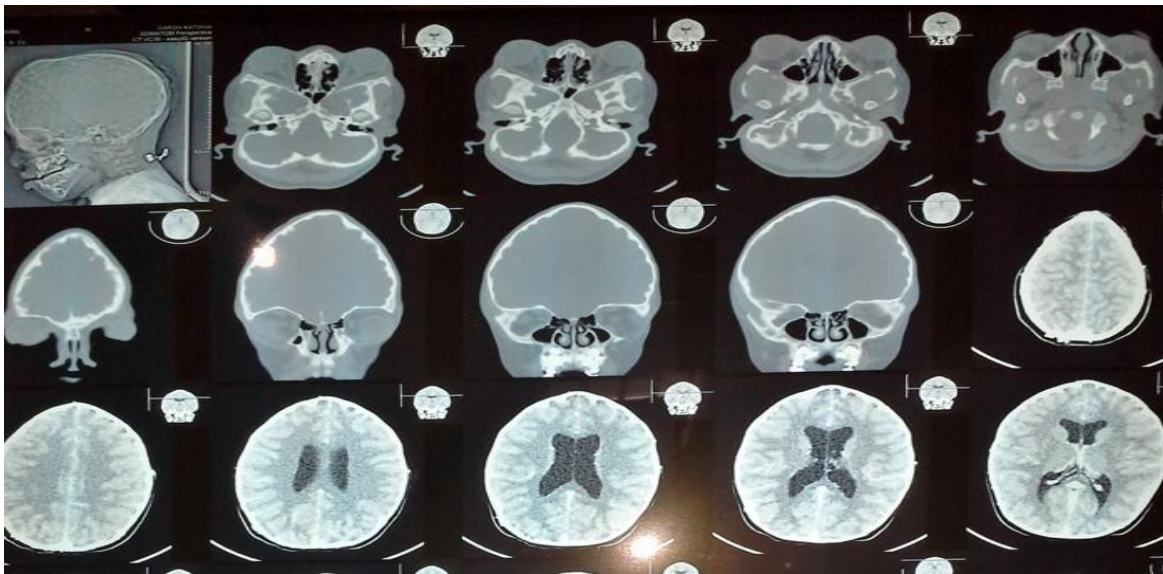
CT Scan showing the shallow orbits and proptosis and brachycephalic cranium.
